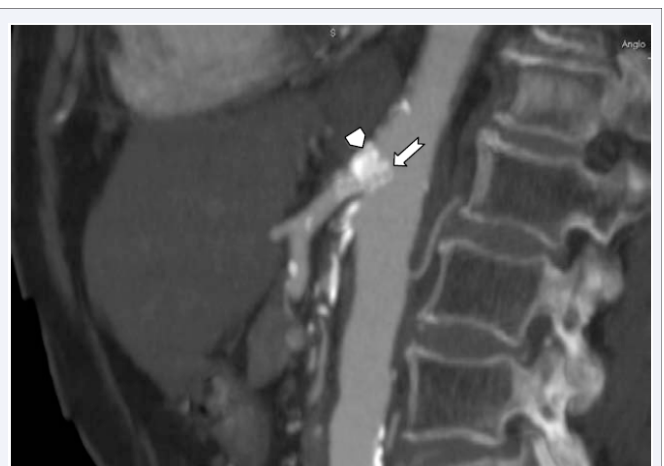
Case 2. Two months follow-up postoperative CTA showing patent stent (arrow) in the CA (note the severe calcification of the CA origin - arrow head).
